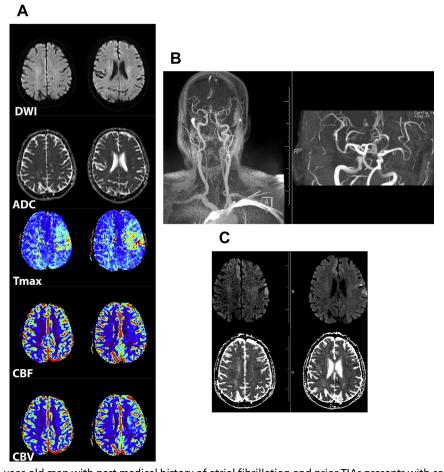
A 67-year-old man with past medical history of atrial fibrillation and prior TIAs presents with complaints of garbled speech for 10 minutes before it resolved. Time of onset to first MR imaging was approximately 2 hours. On initial MR images (A), there is no acute infarction on the DWI-ADC images. Perfusion imaging (A) reveals a regional perfusion deficit evident by increased T<sub>max</sub> involving the left operculum and Broca area. Note compensatory increased in CBV suggestive of autoregulation and luxury perfusion to maintain the CBF. MRA (B) shows a normal proximal arterial tree without evidence of hemodynamically significant stenosis. The patient was discharged from the emergency department with the diagnosis of TIA; however, 14 hours later his garbled speech returned and was noted to be persistent. He also complained of a patch of right-sided upper lip numbness. He was able to follow commands and communicate by writing, but was noted to have a severe expressive aphasia. Second MR imaging (C) reveals restricted diffusion and acute infarction involving the frontal operculum and Broca area, in the region of previously identified delayed perfusion.
